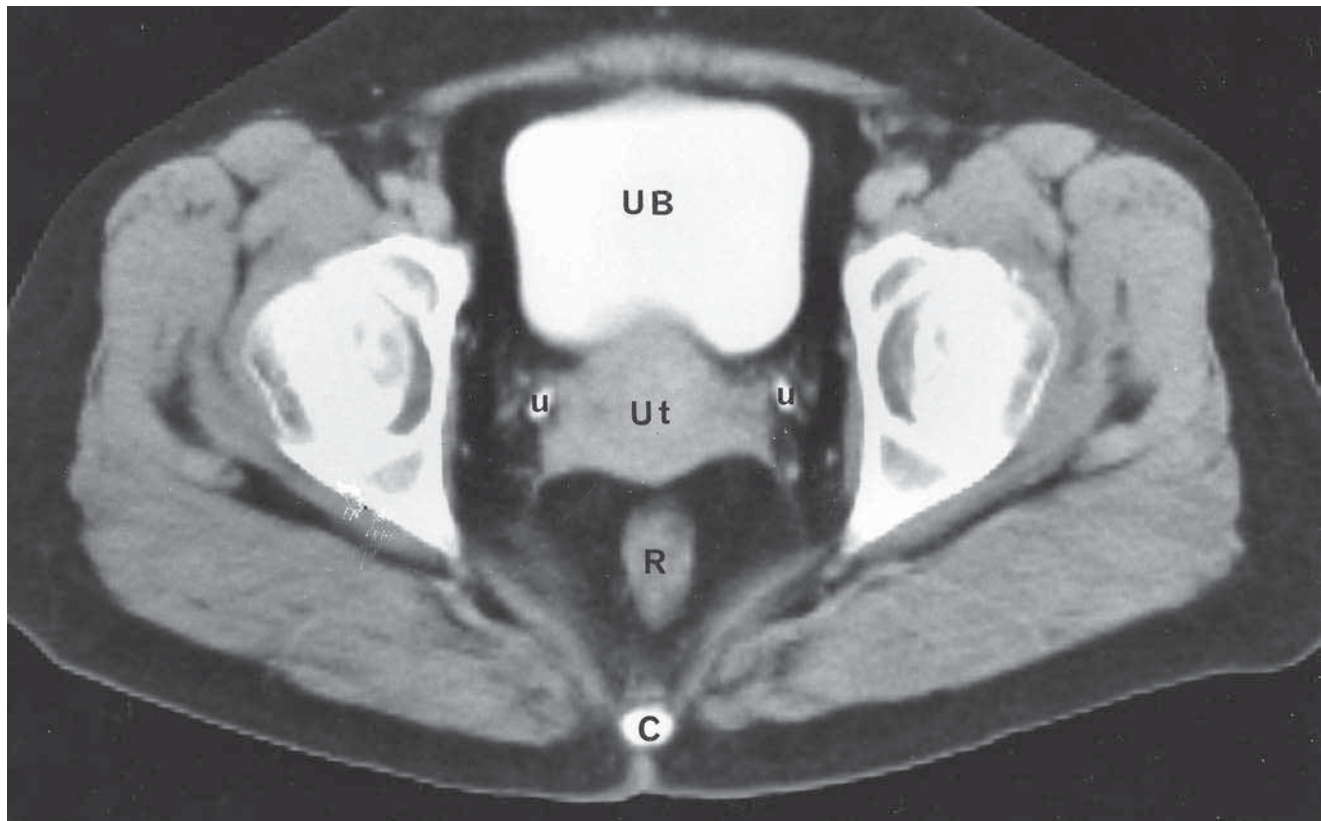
CT of the Female Pelvis
